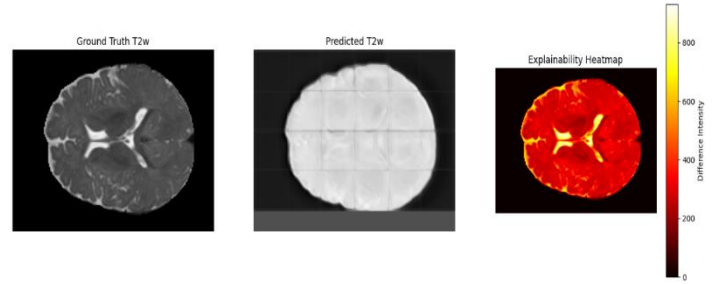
Synthetic MRI with Less accuracy
